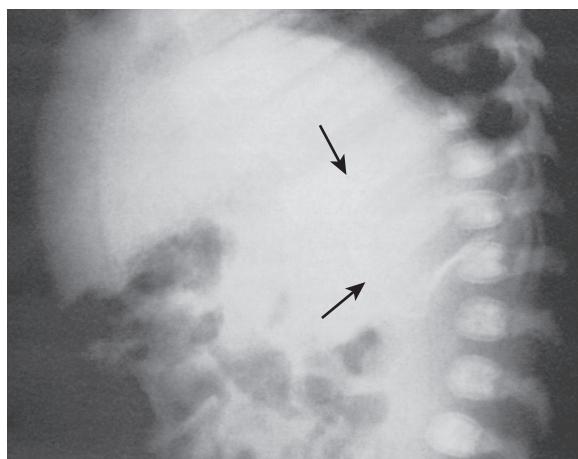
Lateral abdominal radiographs of a 5312-g male infant delivered vaginally, with difficulty after shoulder dystocia. At 48 hours, fever, icterus, and slow feeding were noted, and a mass was palpable above the left kidney. At 31 days, there was dense, retracted calcification (arrows) that assumed the configuration of the adrenal gland.
